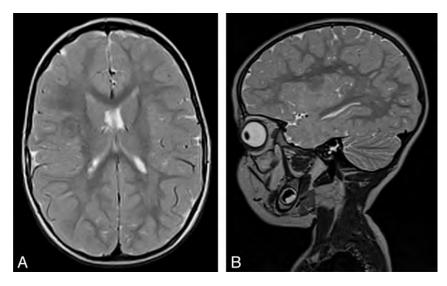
Axial and sagittal T2 MR imaging scan of a 2-year-old girl with tuberous sclerosis in whom right insular epilepsy (definite) developed. Cortical tuber involving the short posterior and long anterior gyri of the insula. Note the white matter abnormalities of tuberous sclerosis.
